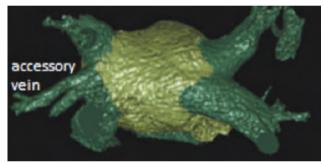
Three-dimensional anatomy of the pulmonary and accessory veins' was constructed by using computed tomography.
